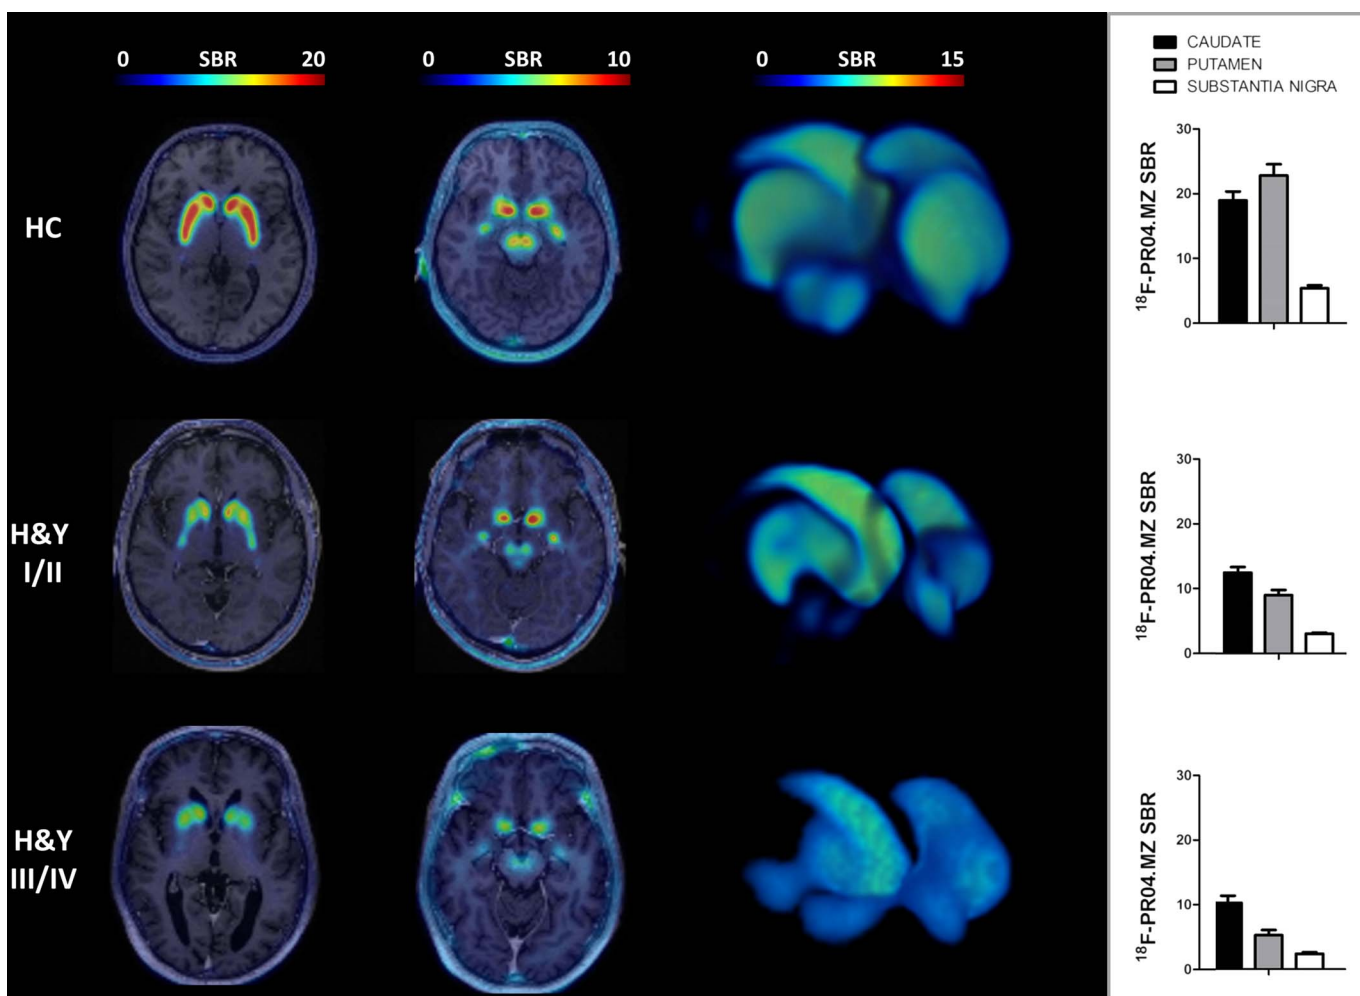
Transversal view of PET images coregistered to corresponding T1-weighted MRIs in striatal region (first column) and midbrain region (second column) for HCs (above), mild PD (middle), and moderate PD (below). Three-dimensional rendered images of $[^{18}\text{F}]\text{PR04.MZ}$ uptake (third column; cutoff for render: SBR 2–15) and mean regional SBR values (fourth column) of HC and PD patients.
